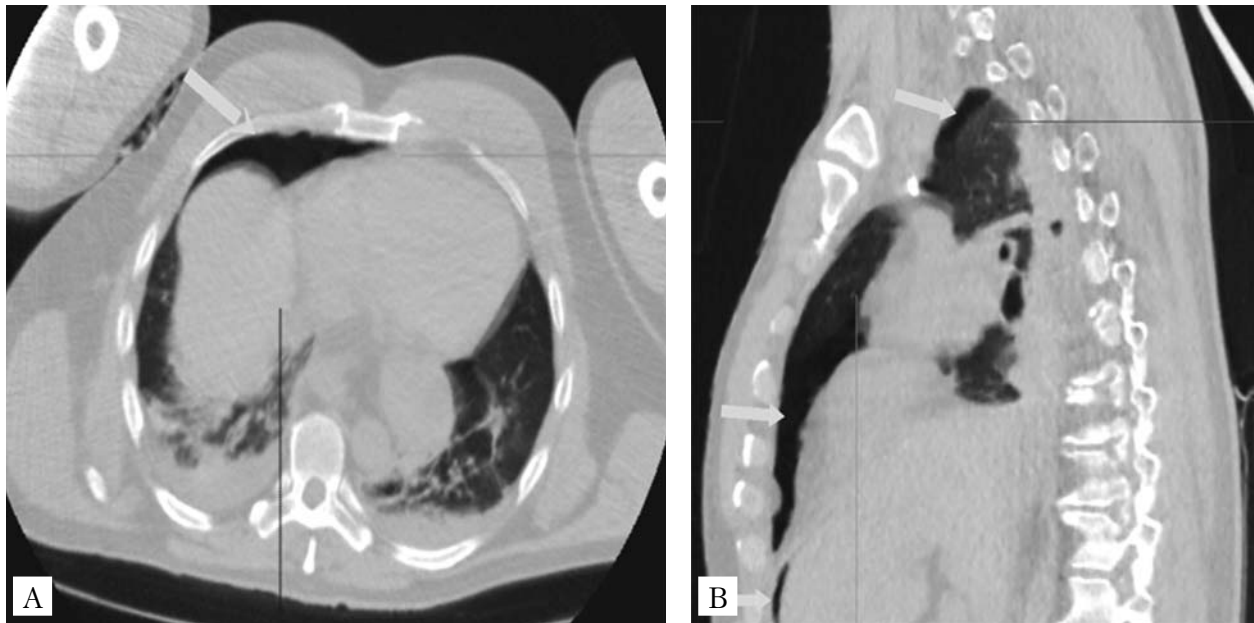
Chest CT scan at the time of admission: A — axial plane: partial right-sided pneumothorax, initial manifestations of posttraumatic pulmonary consolidation; B — sagittal plane: partial right-sided pneumothorax, small pneumoperitoneum
